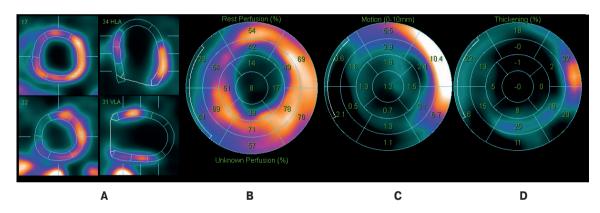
Myocardial perfusion SPECT of the patient with ischemic HF after CCM device implantation. A. Perfusion scintigrams. B. Polar map of LV perfusion. No worsening. Anterior-apical-lateral perfusion defect persists with the development of an aneurysm with an area of 35%. C. Polar map of systolic LV wall motion. LV dilatation, diffuse hypo(a)kinesis, dyskinesis of the apex, apical segments of the lateral, septal walls of LV (signs of fibromuscular aneurysm), EDV of 361 ml, ESV of 299 ml, LVEF of 17% (N>50). D. Polar map of LV systolic wall thickening. Systolic thickening is moderately restored in the inferolateral and anterolateral LV segments.
